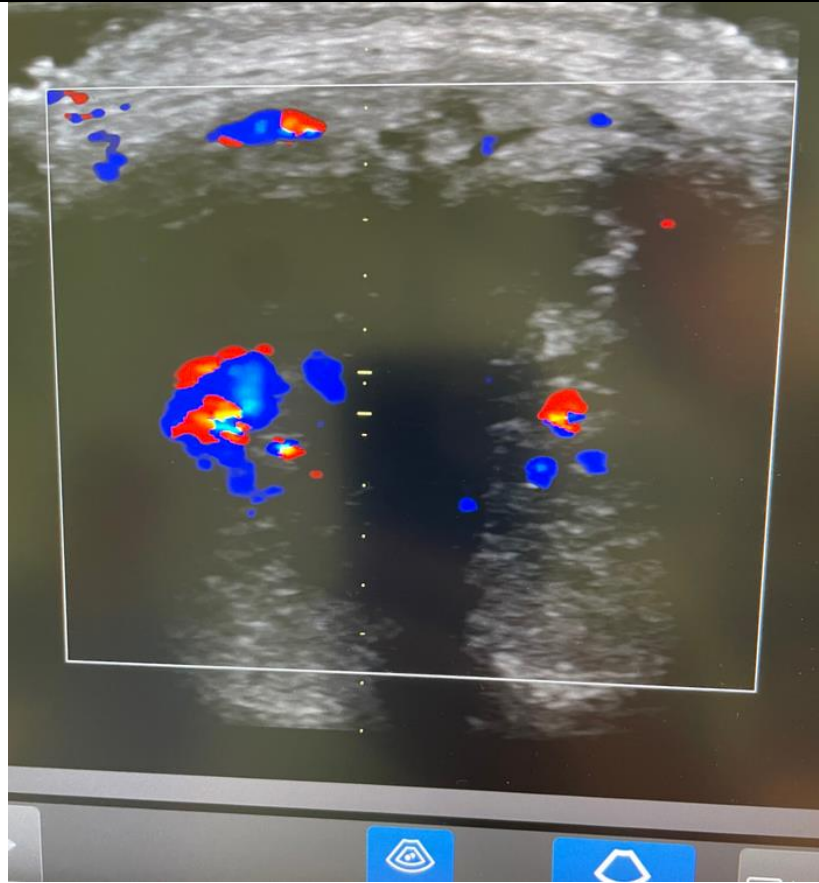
Doppler signal of the corpora cavernosa (post-op day 7): right corpus cavernosum shows better perfusion than the left corpus cavernosum.
